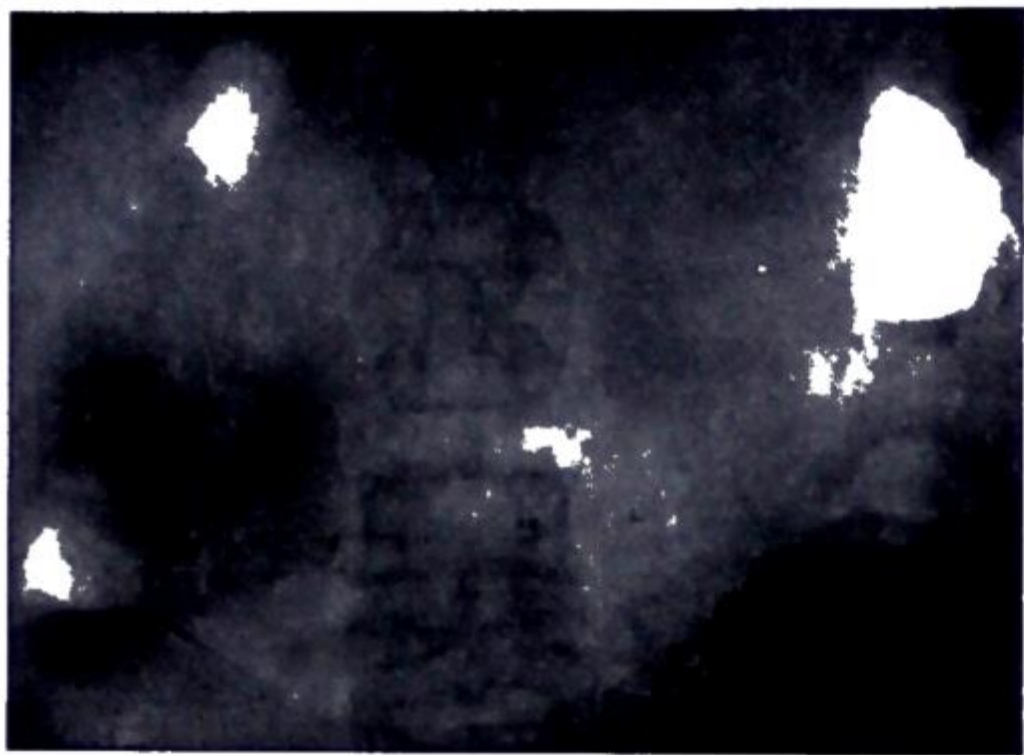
Acute pancreatitis. Radiograph two hours after onset, showing gas in the duodenum and a little in the stomach. (S. Olivier, 'Radio-Diagnostic des Occlusions Intestinales Aiguës,' Paris.)
